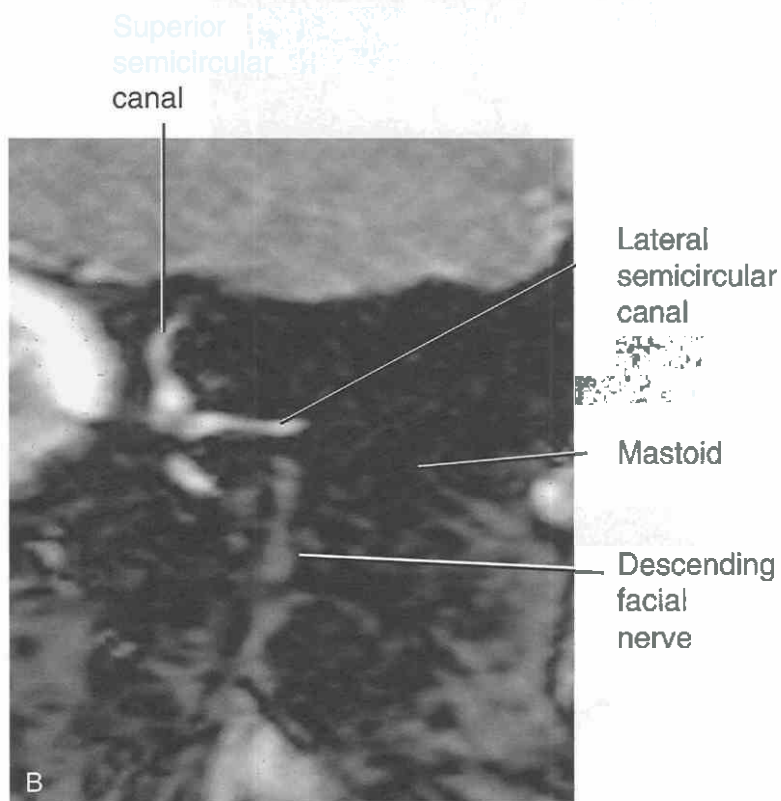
Coronal views, normal anatomy. A, Coronal CT section of the left temporal bone, made through the vestibule and the posterior portion of the oval window. The basal turn of the cochlea and cochlear promontory are seen. The aditus ad antrum is seen just lateral to the lateral semicircular canal. A short portion of the superior semicircular canal is visible. The internal auditory canal, middle ear, styloid process, and external auditory canal are shown. B, Coronal MR section.
